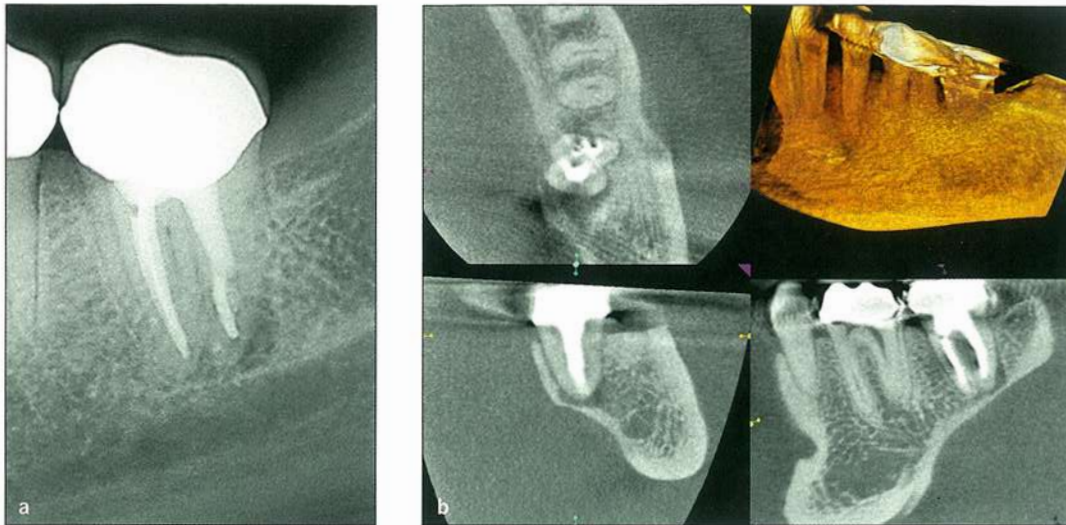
(a) 2D planar view. (b) CBCT scan.
